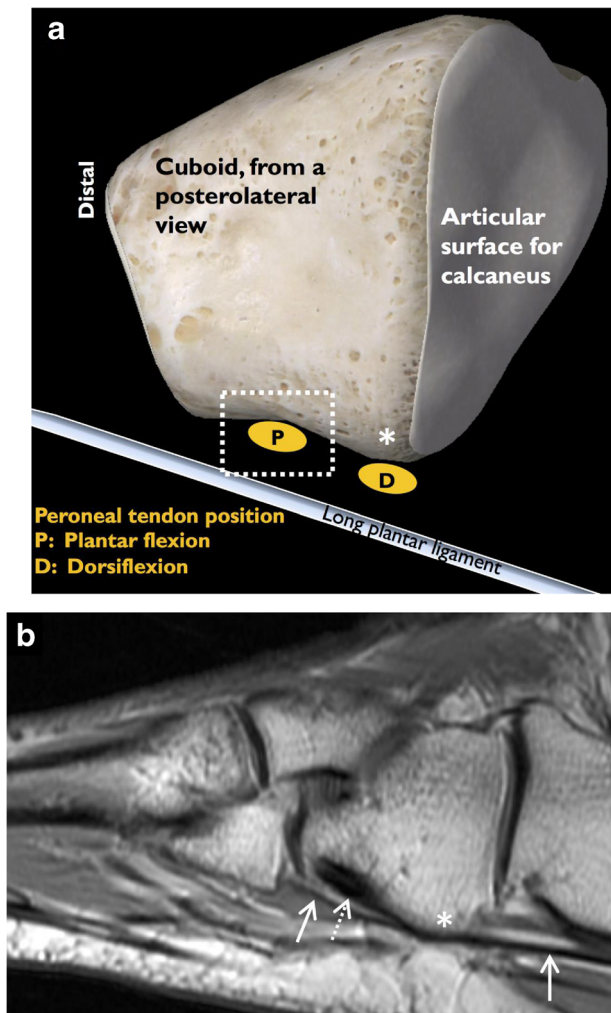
Cuboid tunnel and long plantar ligament anatomy. The graphic (a) and sagittal PD-weighted MR image (b) show the cuboid tunnel (dashed rectangular area) through which the peroneus longus tendon (dashed arrow) travels; the roof is formed by a plantar groove on the cuboid and the floor is formed by the long plantar ligament (solid arrows), which has cuboid and metatarsal base insertions. The position of the peroneus longus tendon within the cuboid tunnel varies with foot position, with proximal subluxation onto the cuboid tuberosity (*) in dorsiflexion
